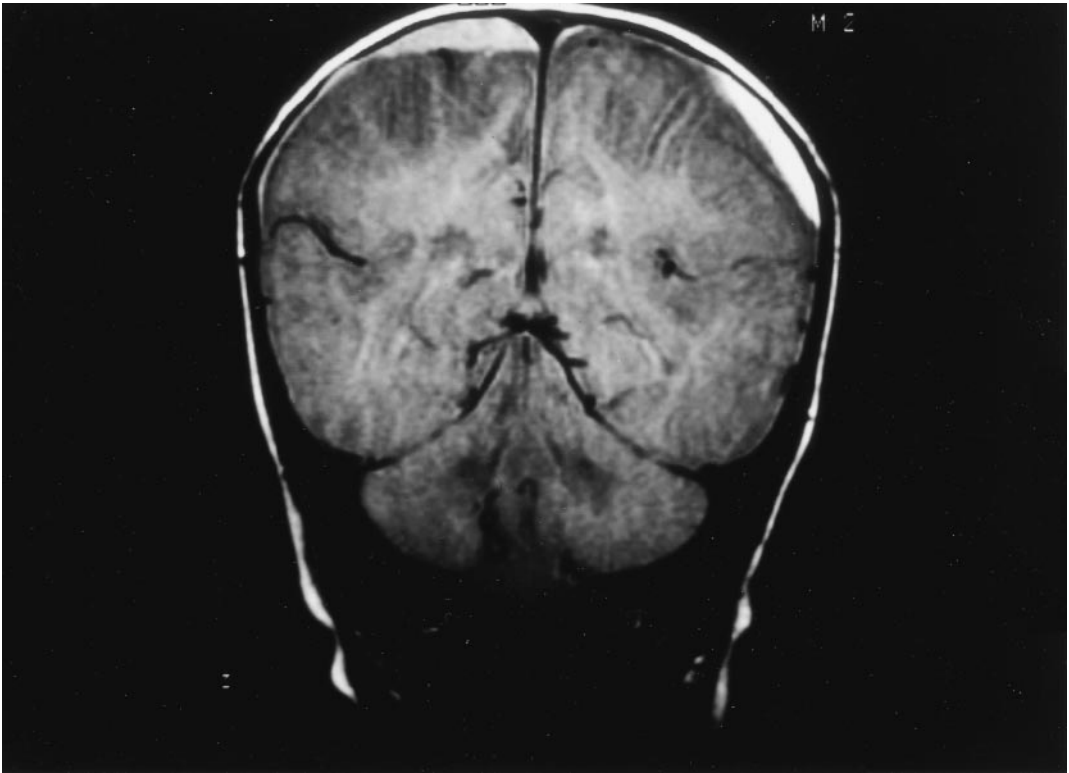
In this same patient (number 4), 15 days later, MRI showed several subdural hematomas.
